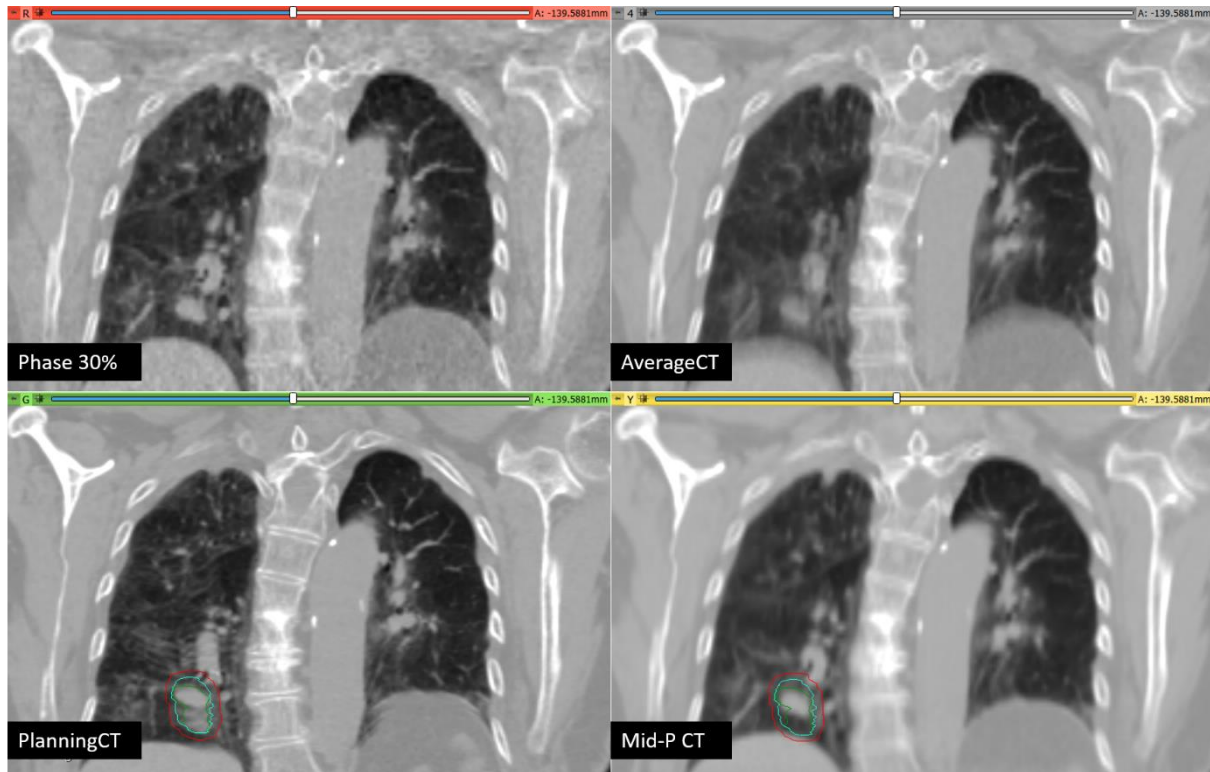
Comparison between phase 30% of the 4DCT scan, Average CT scan, free-breathing planning CT and Mid-P CT scan. Image artefacts in the planning CT due to breathing during CT acquisition led to an inaccurate delineation of CTV (green). The ITV (blue) covers all the tumour positions over the respiratory target and an additional margin is applied to the ITV, composing a larger PTV (red). The Mid-P CT reduces image artefacts, yielding a good representation of tumour and internal structures, which potentially allows the reduction of planning-treatment margins.
